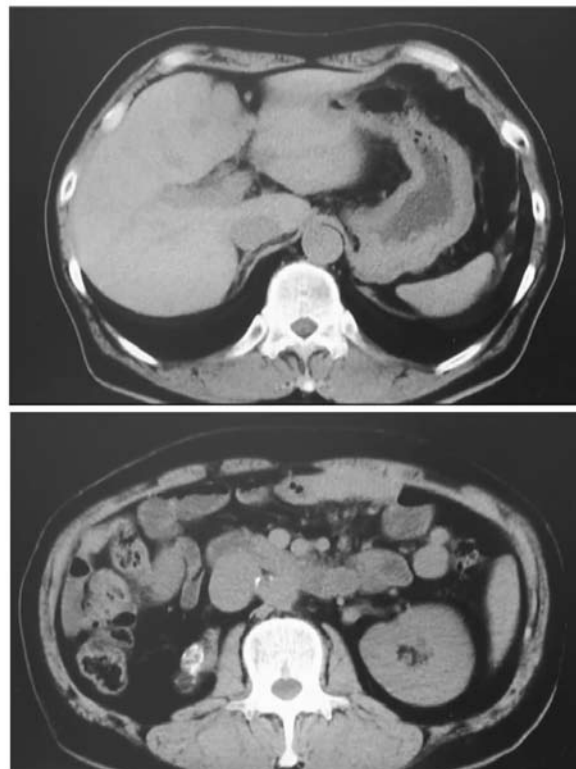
Axial abdominal cavity CT scans
